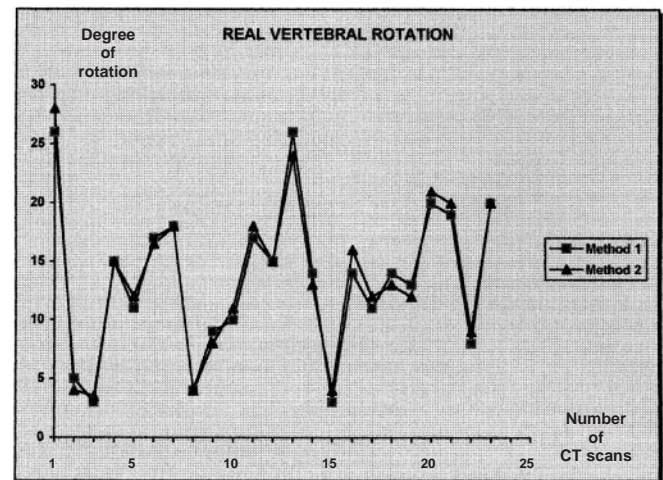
Real vertebral rotation: a comparison of the values obtained by the two CT measurement methods
